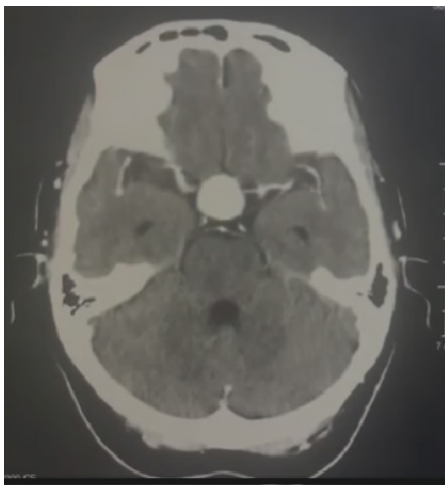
Contrast-enhanced CT scan of the brain showing a saccular aneurysm
